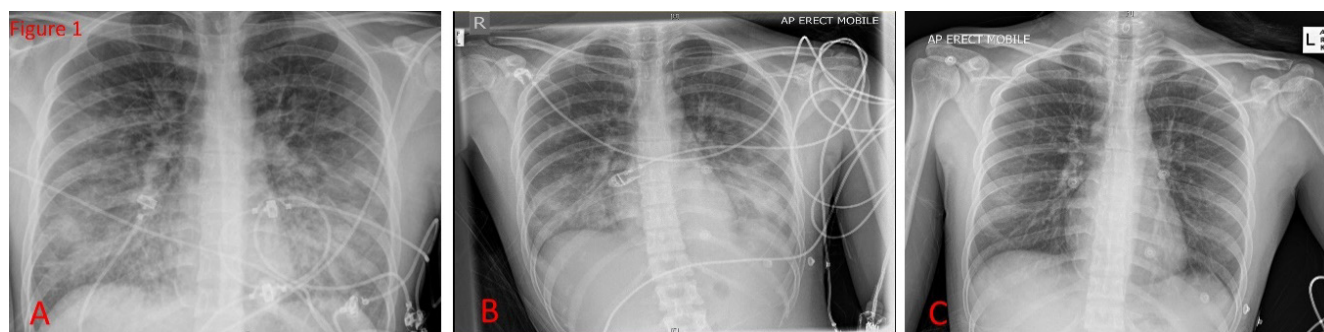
Serial AP Chest-X-rays. A. On admission on non-rebreather mask. B. Day 1 of admission on high flow nasal prongs. C. Day 3 of admission on room air when patient was discharged.
